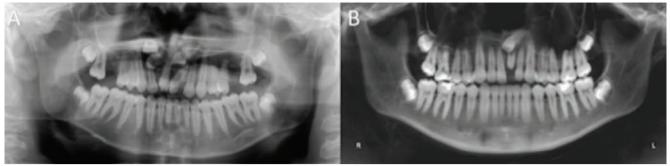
Mesiodentes: causing ectopic eruption of teeth 11 and 21 (A). Intercepting the correct axis of eruption of tooth 21 (B), on panoramic radiographs.
